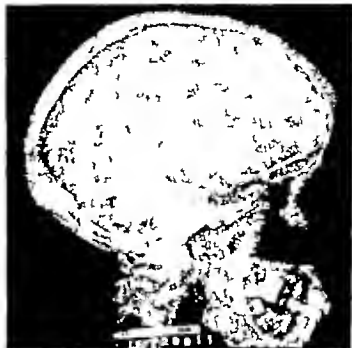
Roentgenogram 4 months following operation to show the striking degree of postoperative remineralization and recalcification of cystic areas (Case XIII)
